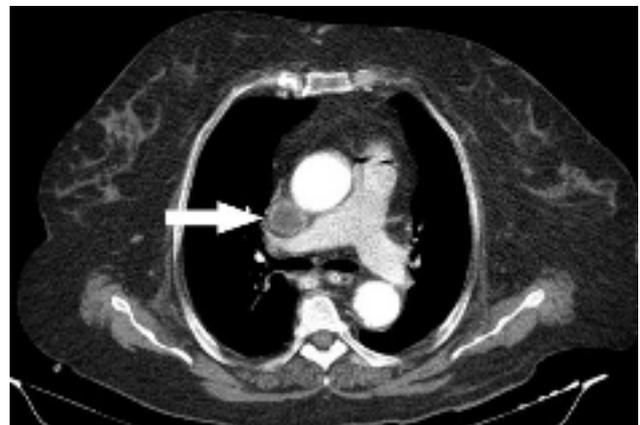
Thorax CT angiography showing occlusion of the superior vena cava
